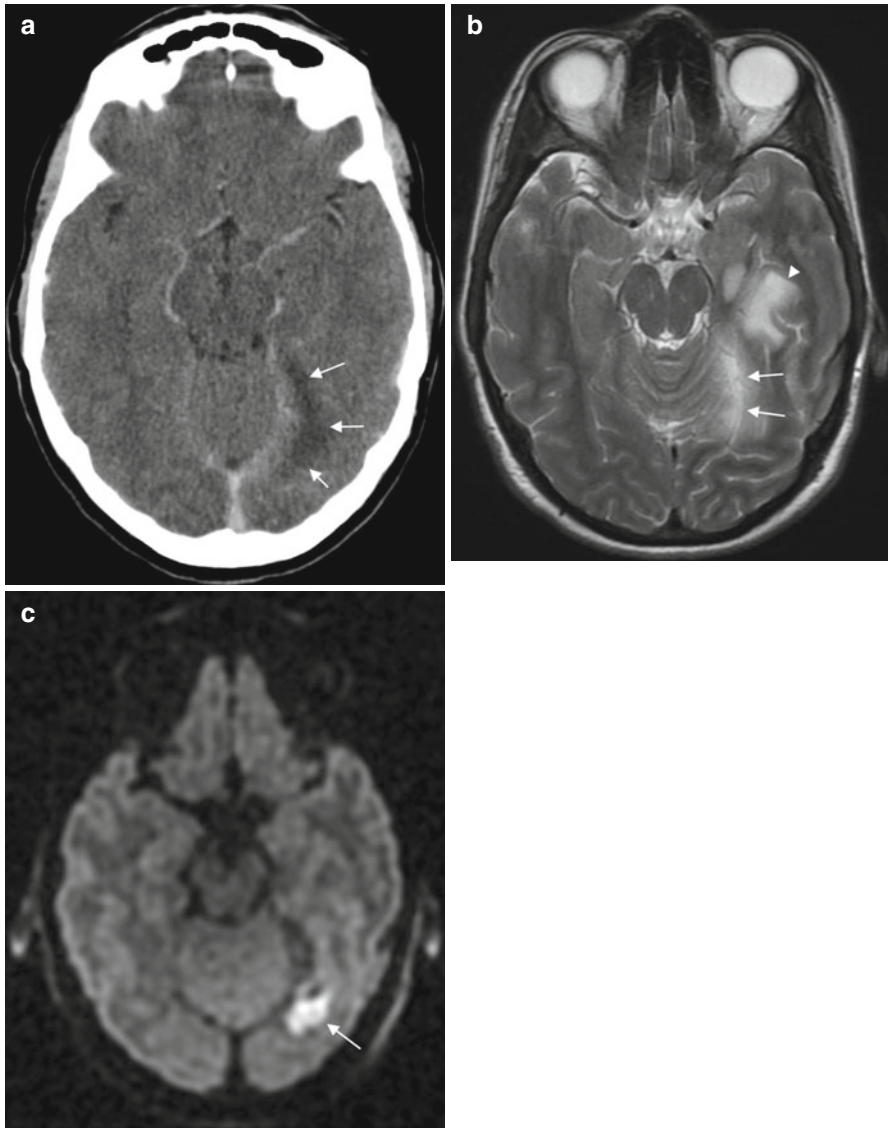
Subdural empyema in a 34-year-old patient. The subdural empyema (*arrows*) is hypodense on CT (a), hyperintense on T2 (b) and hyperintense on diffusion-weighted imaging consistent with infection (c). The associated parenchymal T2 hyperintensity (b, *arrowhead*) is due to cerebritis
